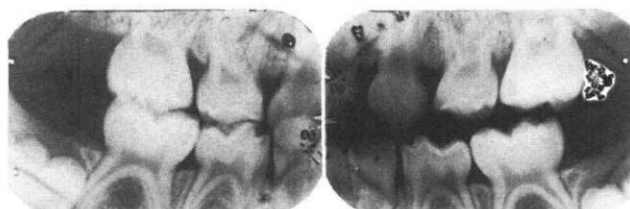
Bite-wing radiographs of Patient 12 also showing normal appearance.
